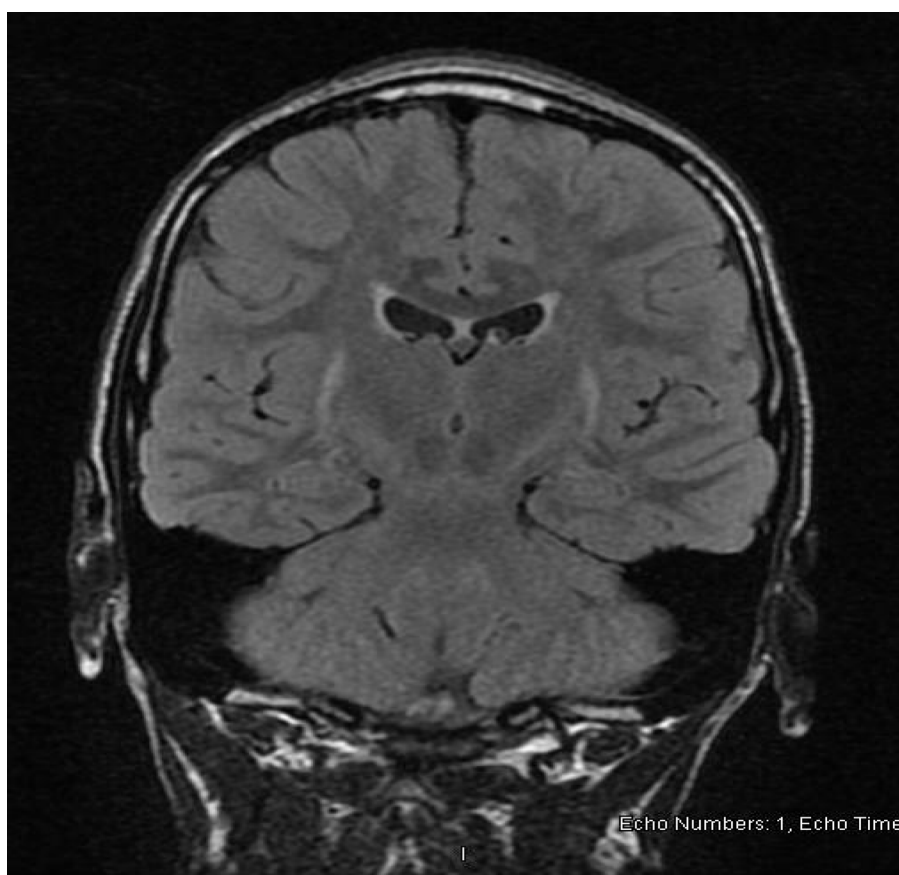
Coronal view T2/FLAIR MRI sequence demonstrating abnormal T2/FLAIR hyperintensities of the bilateral caudate nuclei and putamina.
